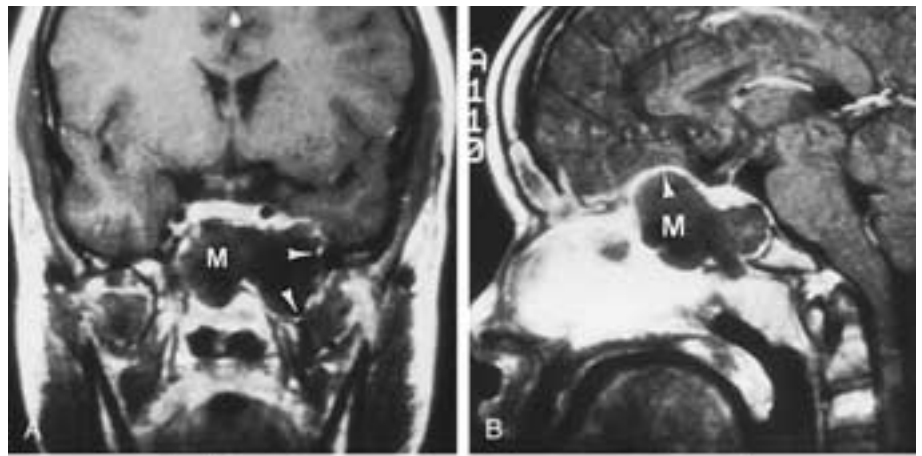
A, Mucocoele of the sphenoid sinus. Coronal image shows the mucocoele (M). There is expansion laterally (white arrowheads) in the position that would be typical of a lateral sphenoid air cell. The low signal on this postcontrast T1-weighted image is thought to be caused by very high protein content and desiccation. It might also be due to *Aspergillus*, which would give a very low signal. B, Postcontrast T1-weighted sagittal image shows the mucocoele with upward expansion in the region of the planum (white arrowhead). Again, note the low signal and lack of enhancement in the mucocoele cavity. C, Coronal CT image. The mucocoele expands the planum and the cortex superiorly (small arrowheads).
